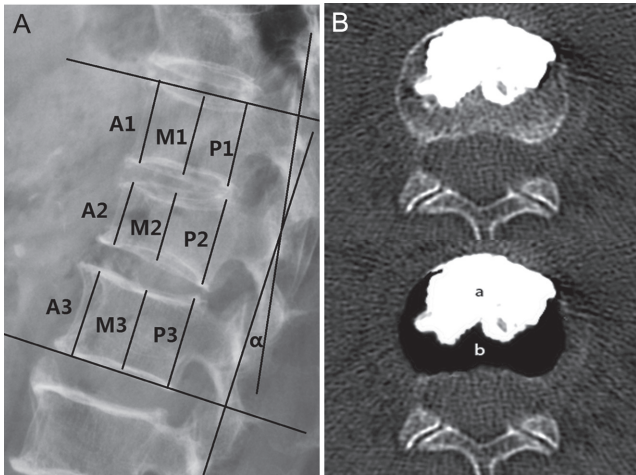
A-B. Methods of measurements on images. (A) Lateral radiograph showing evaluation of the Cobb angle, AVBhr, MVBhr, and PVBhr. The Cobb angle = α , AVBhr = $2 \times A2 / (A1 + A3)$, MVBhr = $2 \times M2 / (M1 + M3)$, and PVBhr = $2 \times P2 / (P1 + P3)$. (B) CT plain image showing the evaluation of cement distribution. Cement distribution of a single CT section = $a / (a + b)$. Cement distribution was calculated as the mean of all CT sections of the treated vertebra. AVBhr, anterior vertebral body height ratio; CT, computed tomography; MVBhr, middle vertebral body height ratio; PCBhr, posterior vertebral body height ratio.
